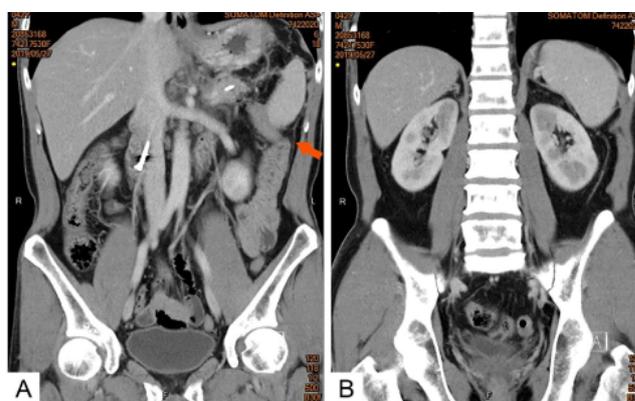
Post-operative abdominal CT. A: Resolution of the mass-like stricture of the descending colon (broad arrow); B: Resolution of pancreatic pseudocysts and return of left kidney to normal anatomic position.
